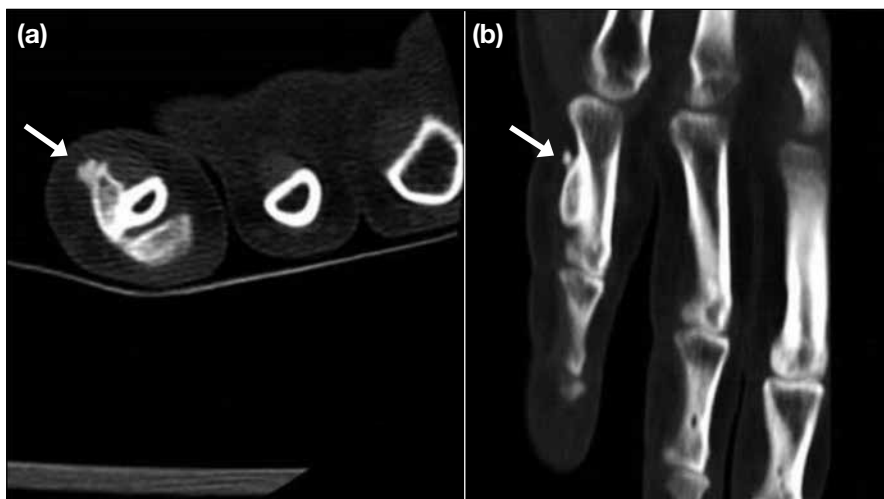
Computed tomography images belonging to the same patient in Figure 18. (a) Axial and (b) coronal computed tomography images of the left fingers showing the corresponding ossified lesion (arrows) as a broad-based juxtacortical lesion without medullary continuity.
